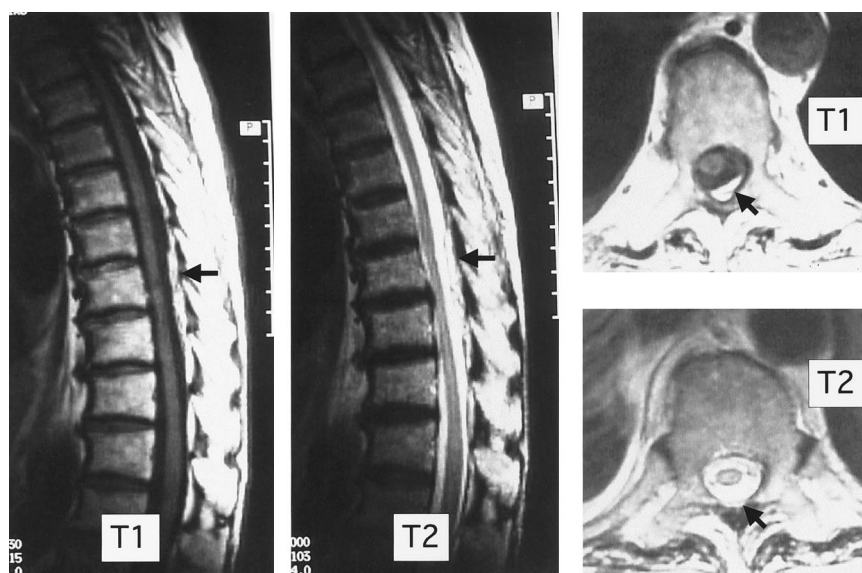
Magnetic resonance images (MRIs) on postoperative day 14. Sagittal T1- and T2-weighted MRIs show that the hematoma still exists from the Th6 to the Th9 level, but it is smaller than it was on postoperative day 3, and compression of the spinal cord has disappeared. Arrows indicate the hematoma at the Th7 level in axial and sagittal MRIs.
